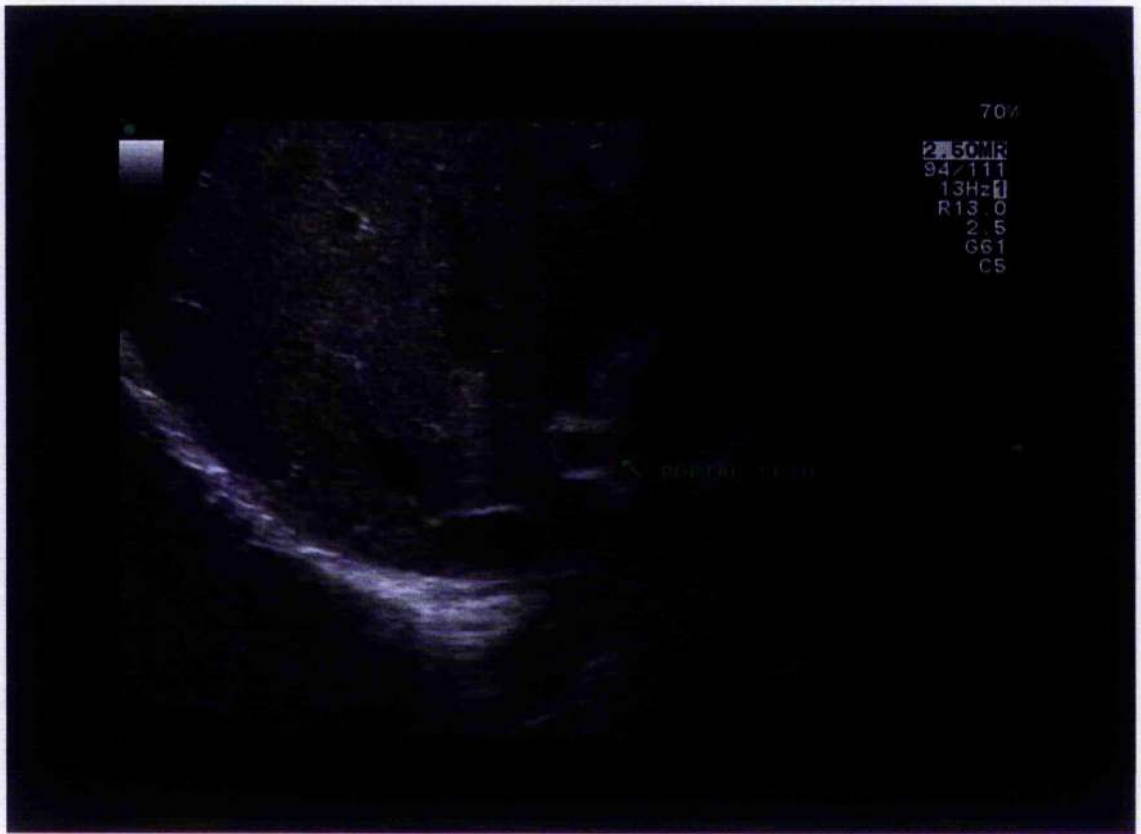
Figure G Baseline ultrasound image showing cross section of portal vein and right lobe of liver.
